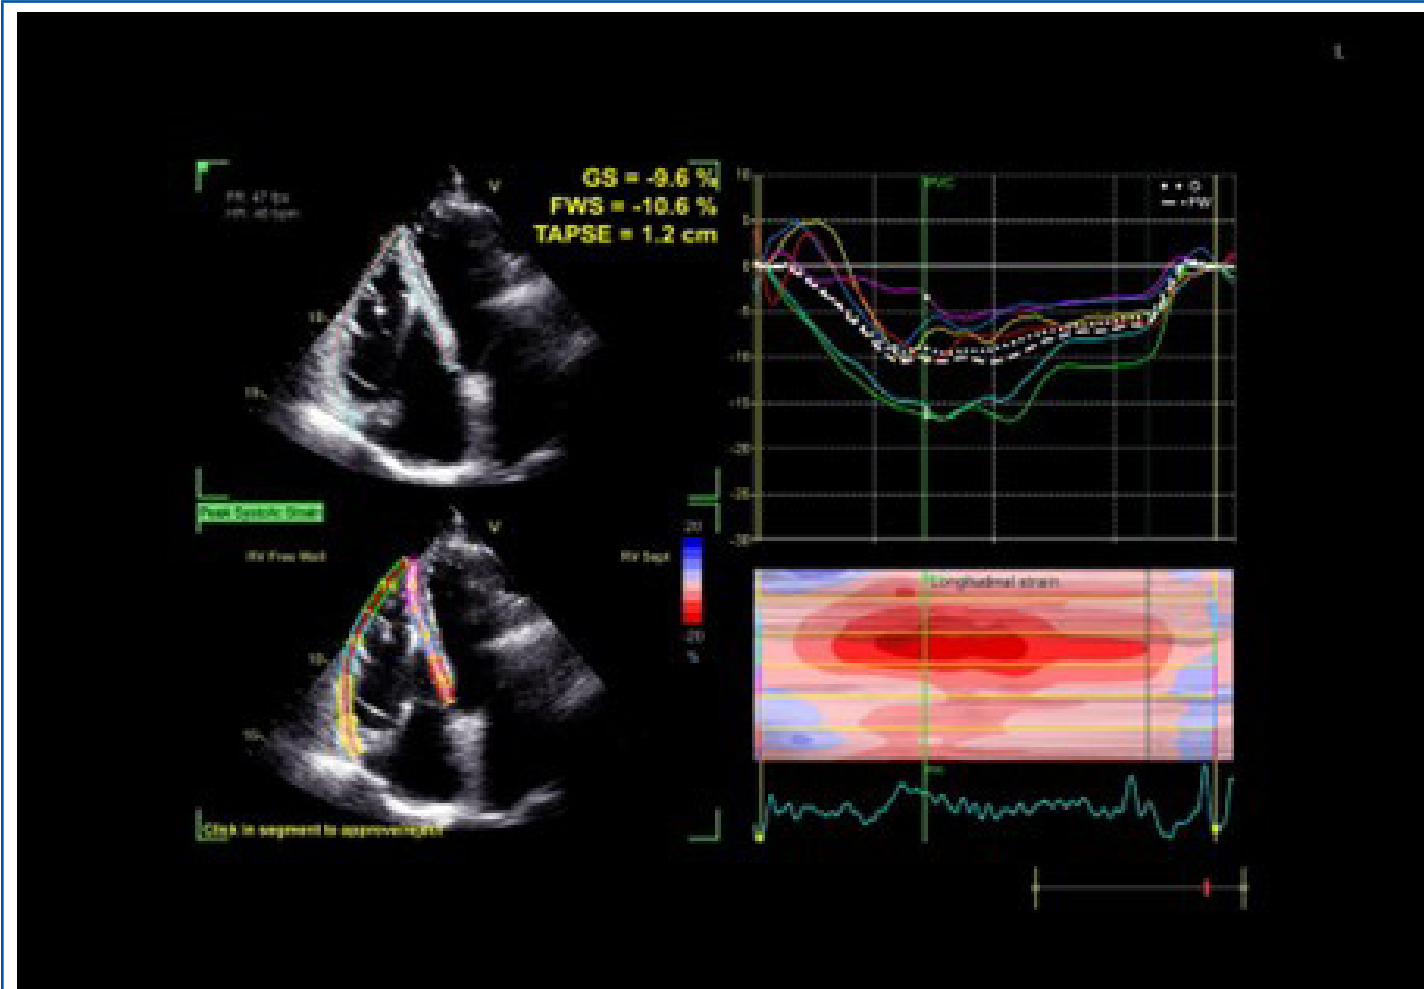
Transthoracic 2D speckle tracking echocardiography showing severely reduced RV strain. 2D, two-dimensional; RV, right ventricular.
